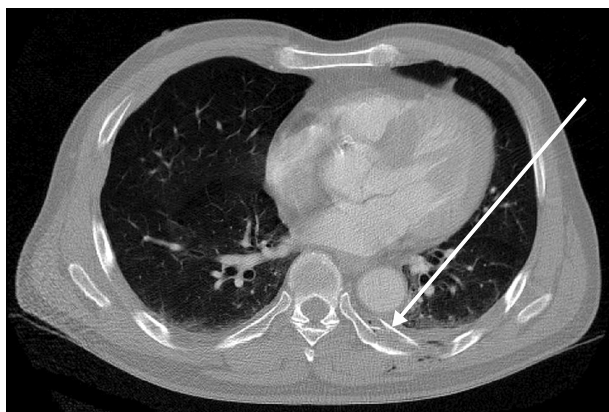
Initial chest computed tomography (arrow: fractured fragment of 7th rib).
